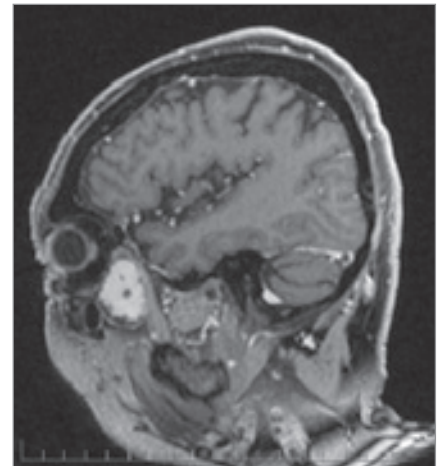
Pre-operative MRI – second case.
